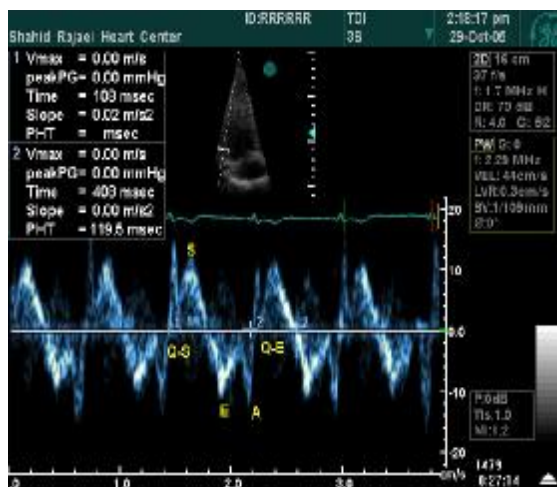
Doppler imaging depicting systolic and diastolic waves.
